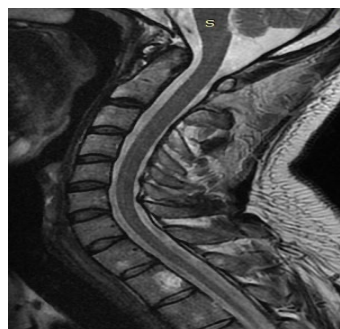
Native Cervical MRI - discrete C5 disc overflow, without visible signs of compression and spinal static disorder
